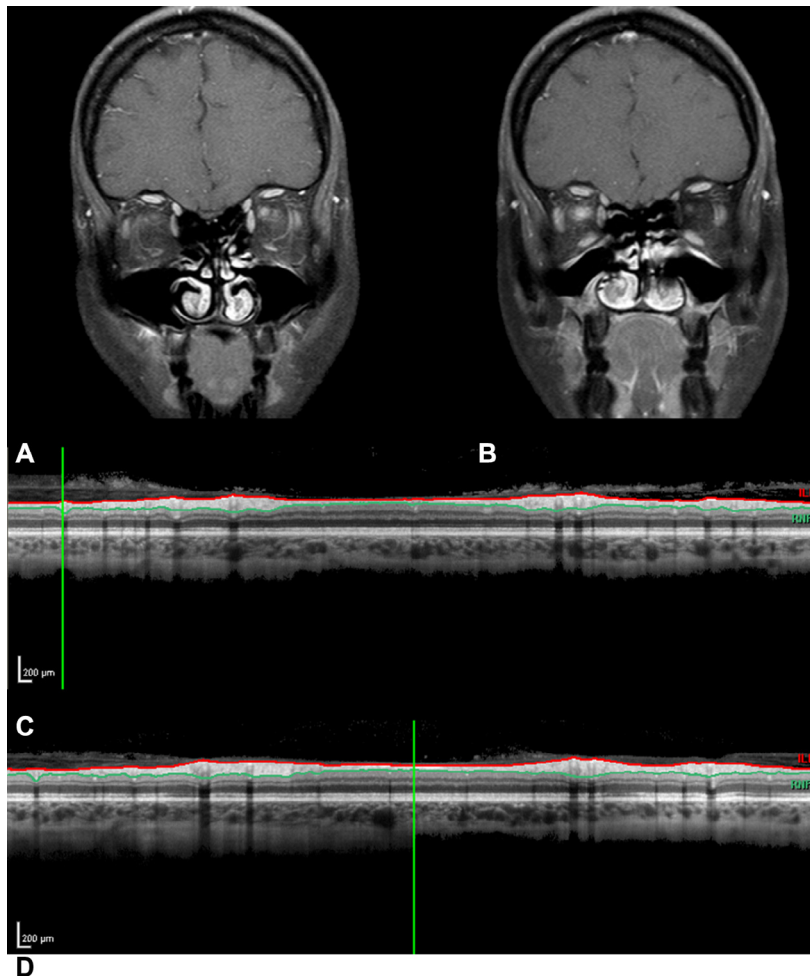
Relapsing, sequential, bilateral optic neuritis in an own case with serum anti-myelin/oligodendrocyte glycoprotein (MOG) IgG autoantibodies. (A) The first magnetic resonance imaging (MRI: coronal short-tau inversion recovery with contrast) was taken during an episode of acute left optic neuritis. (B) The second MRI was taken a year later during an episode of acute right optic neuritis. Both MRIs show contrast enhancement of the respective optic nerves. There was severe atrophy of the posterior retinal nerve fiber layer on (C) the right and (D) the left.
